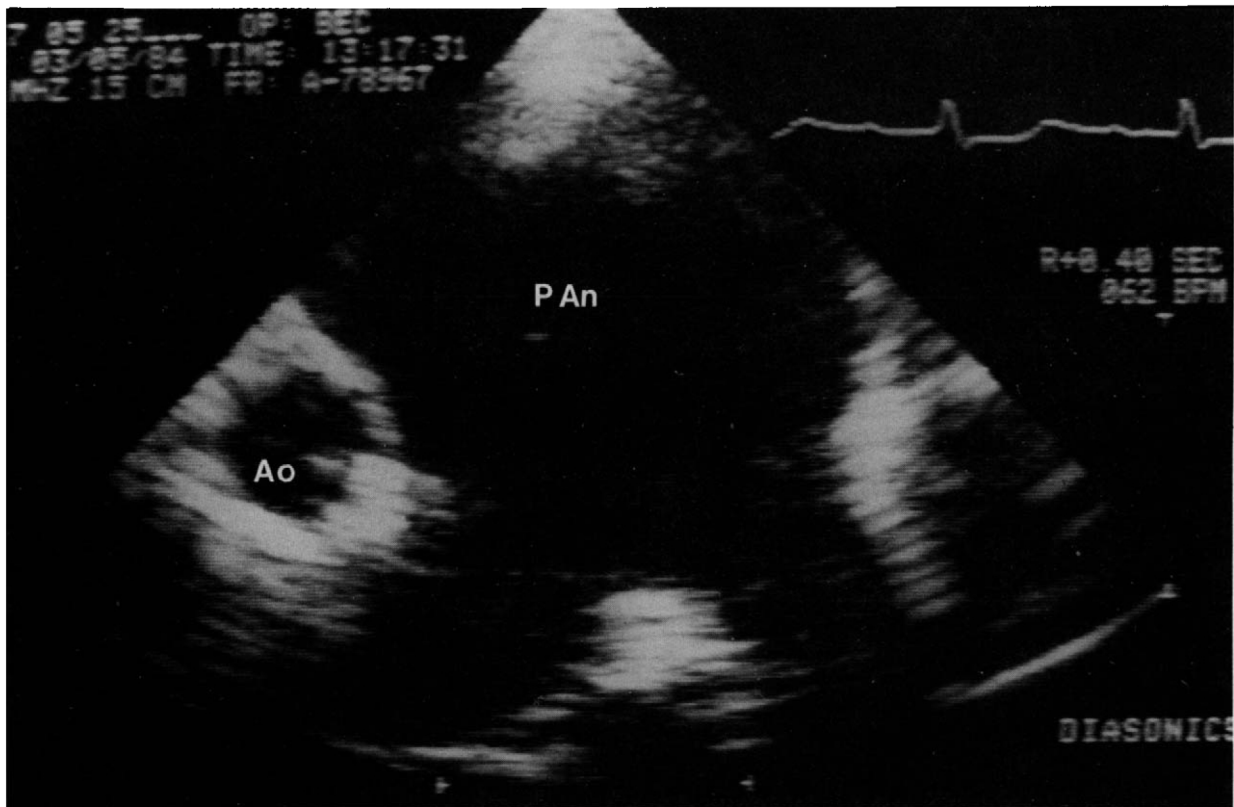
Parasternal short axis two-dimensional echocardiogram of the pulmonary aneurysm (PAn) in the area of the pulmonary artery bifurcation. Ao=aorta.
